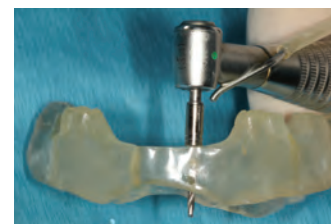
Radiographic guide was modified to create a flat stop for the drill stop, allowing 8 mm of penetration into the mucosa and alveolar bone
